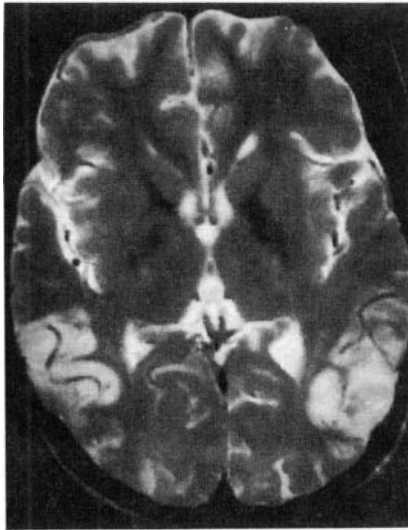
Subacute sclerosing panencephalitis. In another patient the abnormality on T2-weighted image (a) is more widespread compared to Fig.9 involving the occipital and right frontal lobes. However, the T1-weighted image (b) does not show any obvious abnormality.
